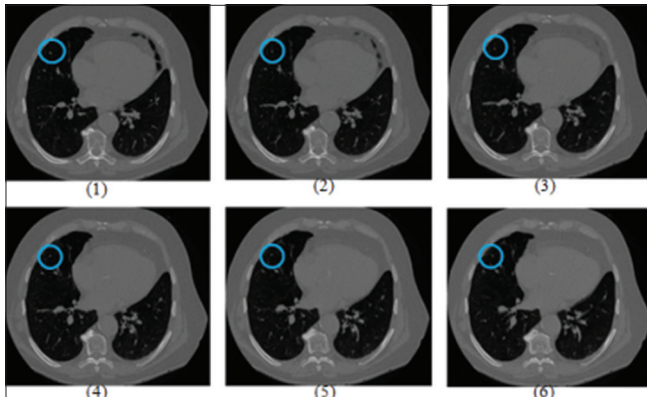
Vessel shown inside the blue circles in consecutive six computed tomography slices, vertical to computed tomography cross-plane
